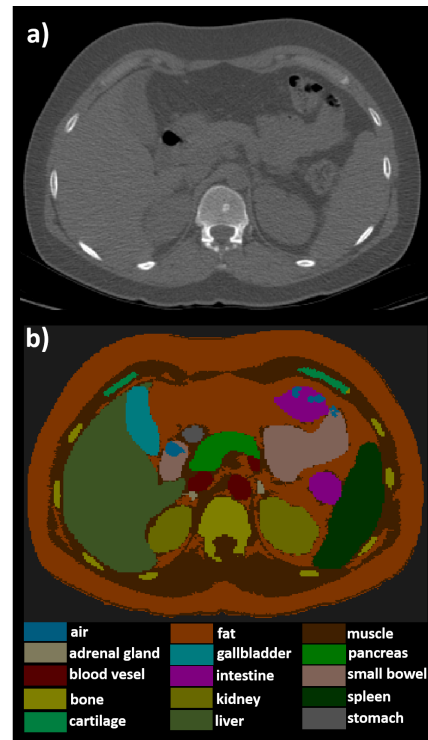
a) axial CT image, b) segmented CT image in iSeg including internal organs.
